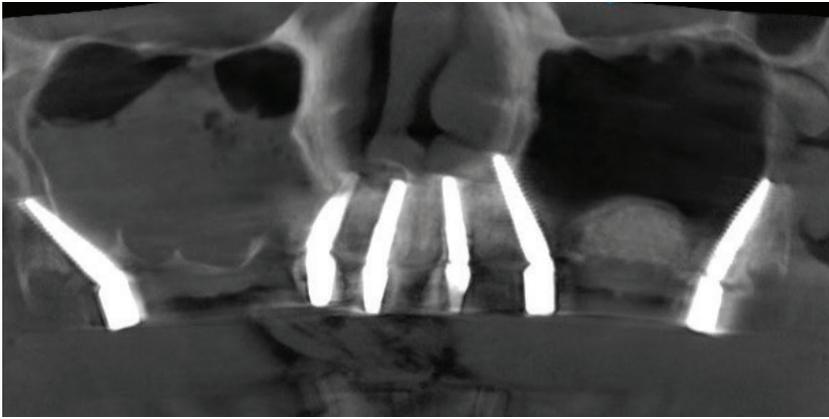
Radiograph demonstrating bicortical fixation with sinus or nasal floors
